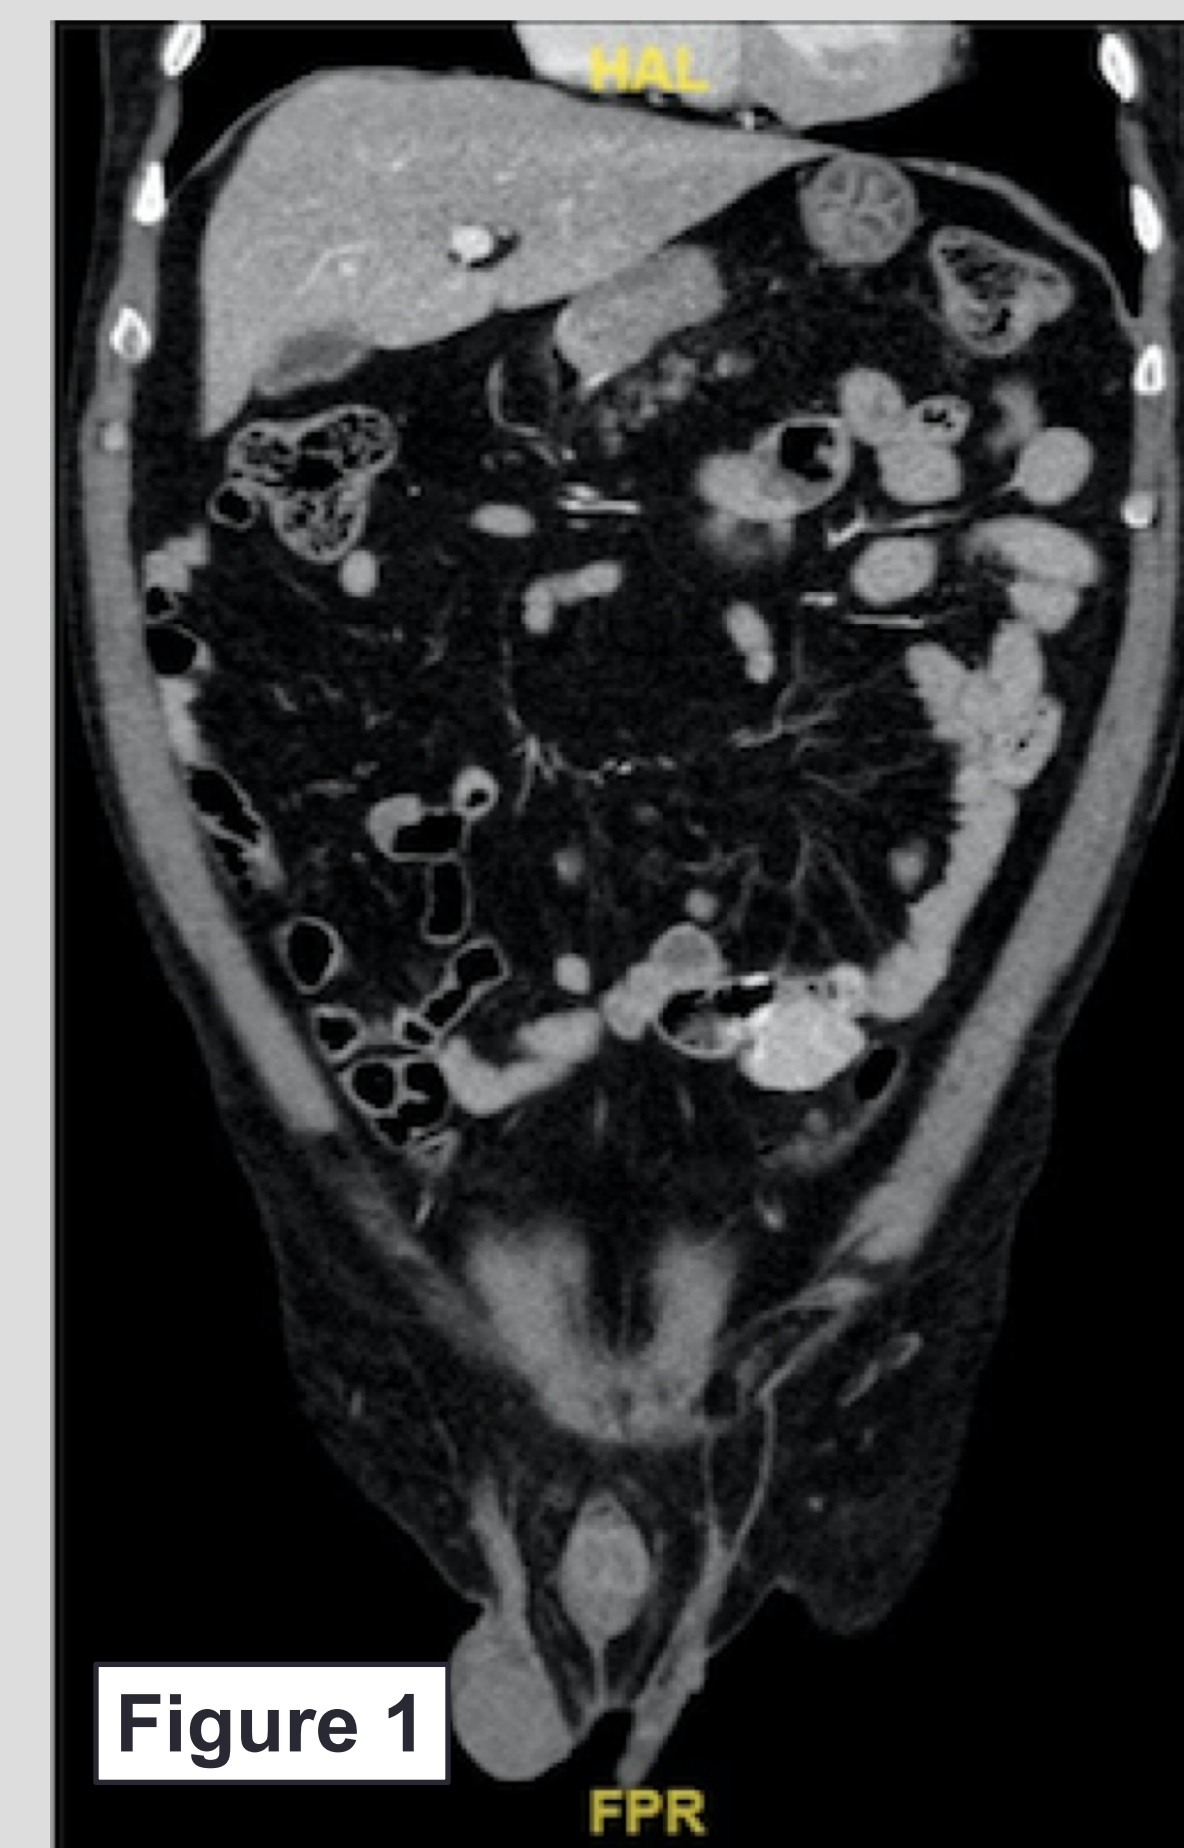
CT Abdomen and Pelvis with contrast demonstrating a 4 cm circumscribed hyperdense enhancing exophytic solid mass arising from the small bowel in the left lower quadrant.
